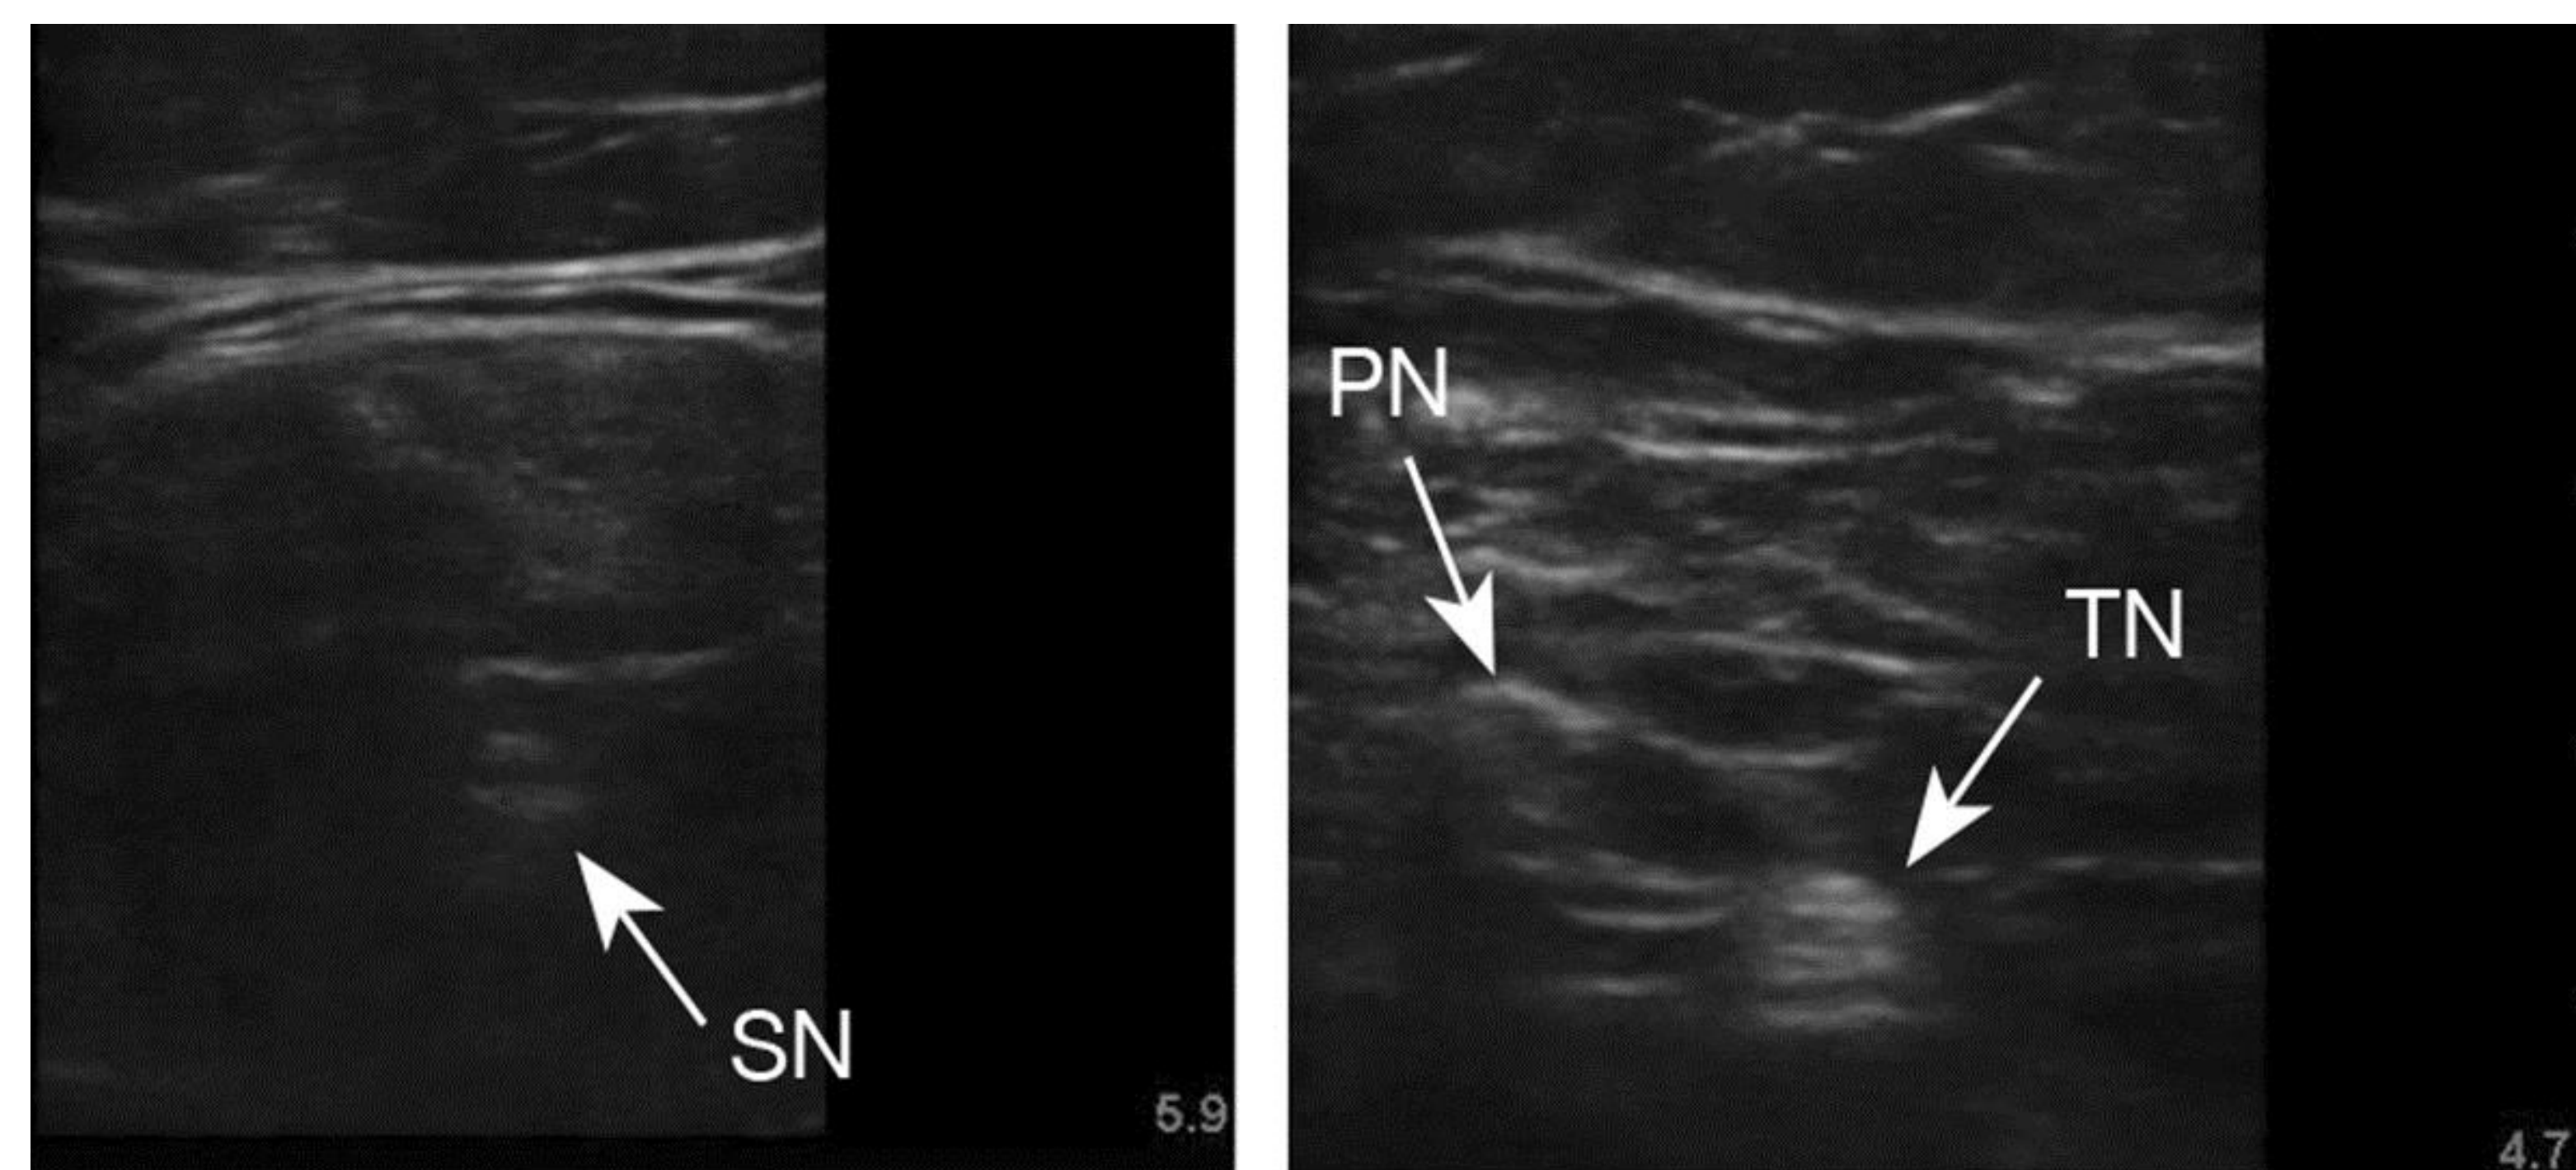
Figure One: Ultrasound images of the popliteal fossa on a study participant. Note the improved visualization as the probe is moved distally. SN: sciatic nerve; PN: peroneal nerve; TN: tibial nerve
